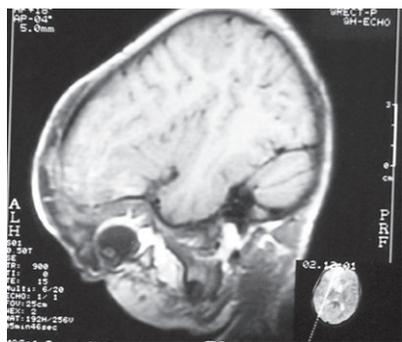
MRI (T1WI, sagittal) showing CSF collection in the right upper eyelid
